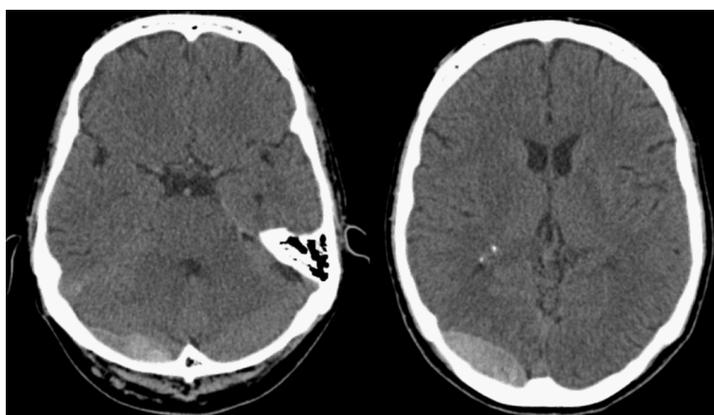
Computed tomography scan performed 48 h after the trauma. An increase of the size of the hematoma was identified by the radiologist. As a consequence we decided to postpone the administration of low molecular weight heparin.
